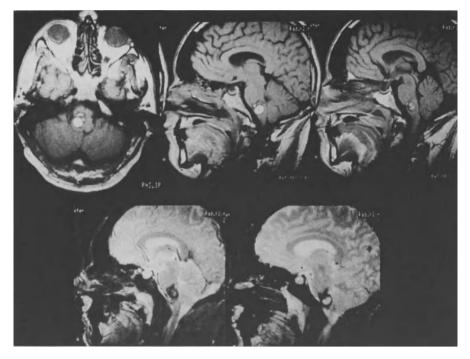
MR images from a patient who presented with a sudden onset of right-sided dysesthesia and diplopia. On CT scan a fresh pontine hemorrhage was seen. The images demonstrate the discrepancy between the size of the hemorrhage and the neurological symptoms
